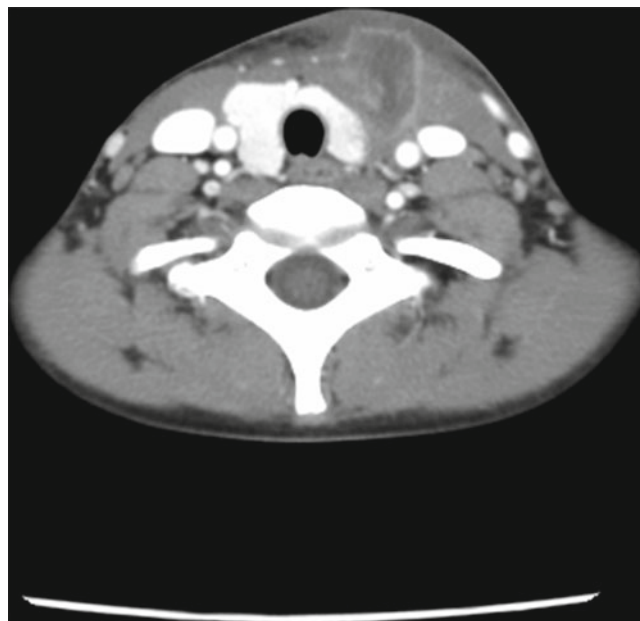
Axial contrast-enhanced CT of a 9-year-old patient with recurrent abscess of the left lower neck related to an underlying third or fourth branchial cleft anomaly. This is located just anterior to the left thyroid lobe (with some involvement) and extends to the left pyriform sinus
